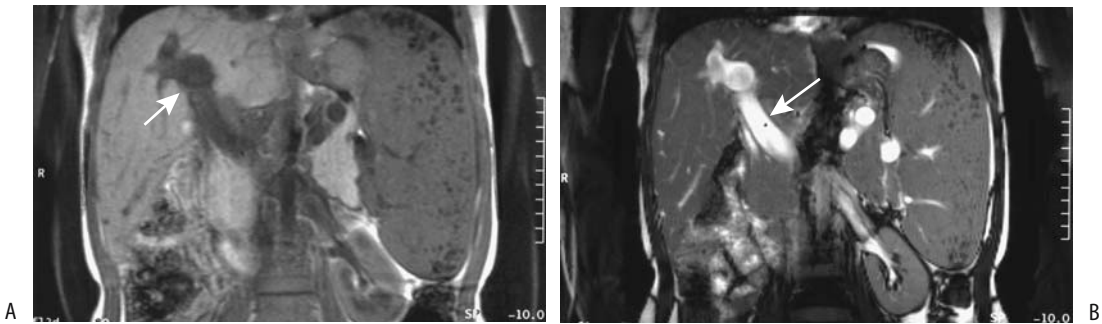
Portal hypertension induced by schistosomiasis. T1- (A) and T2-weighted (B) coronal MR images reveal a spleen larger than the normal-sized liver and a dilated portal vein (arrows). (Source: Burgener FA, Meyers SP, Tan RK, Zaunbauer W. *Differential Diagnosis in Magnetic Resonance Imaging*. Stuttgart: Thieme, 2002, with permission.)
